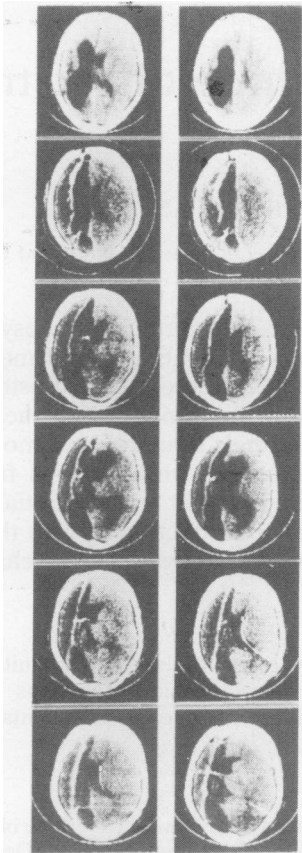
Serial CT scans to show the evolution of early post-operative hydrocephalus, the natural enlargement of the remaining hemisphere and the maintenance of the extradural cavity.
